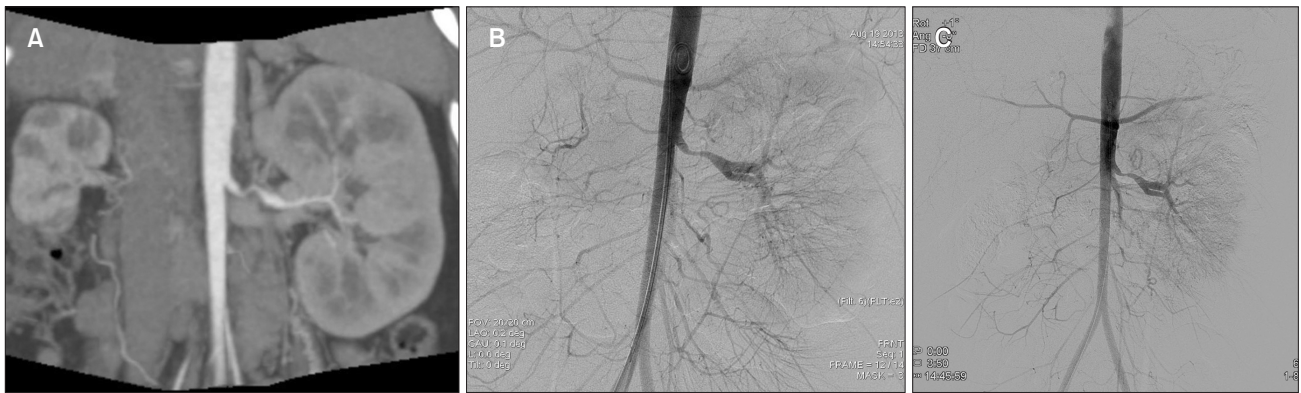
(A) Computed tomography coronal image showed atrophic right kidney due to total occlusion of the right renal artery and severe stenosis of the left renal artery (LRA). (B) Angiography confirmed severe stenosis of the LRA. Percutaneous transluminal angioplasty (PTA) was carried out on the LRA. (C) Angiography 3 months after PTA revealed restenosis requiring repeated angioplasty.
